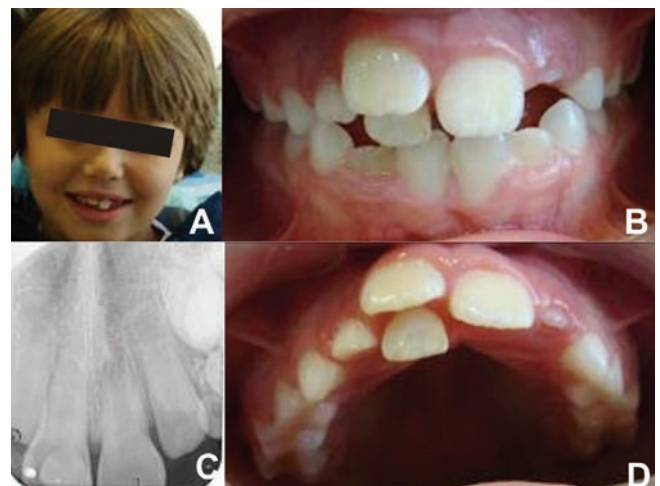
A) Frontal view of the patient's face - twin 01 B) Photography of frontal view of tooth 51. C) Periapical radiography of teeth 11, 21 and 51. D) Photography of occlusal view of tooth 51.
